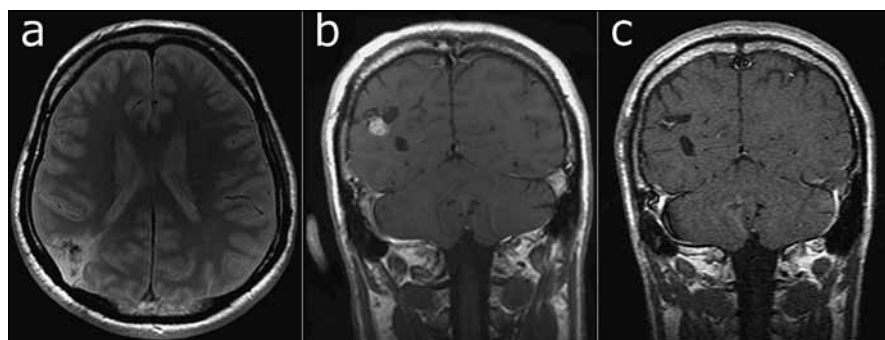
T2-weighted TSE sequence. A hypointense nodule is visible within a wedge-shaped lesion in the angular region.
